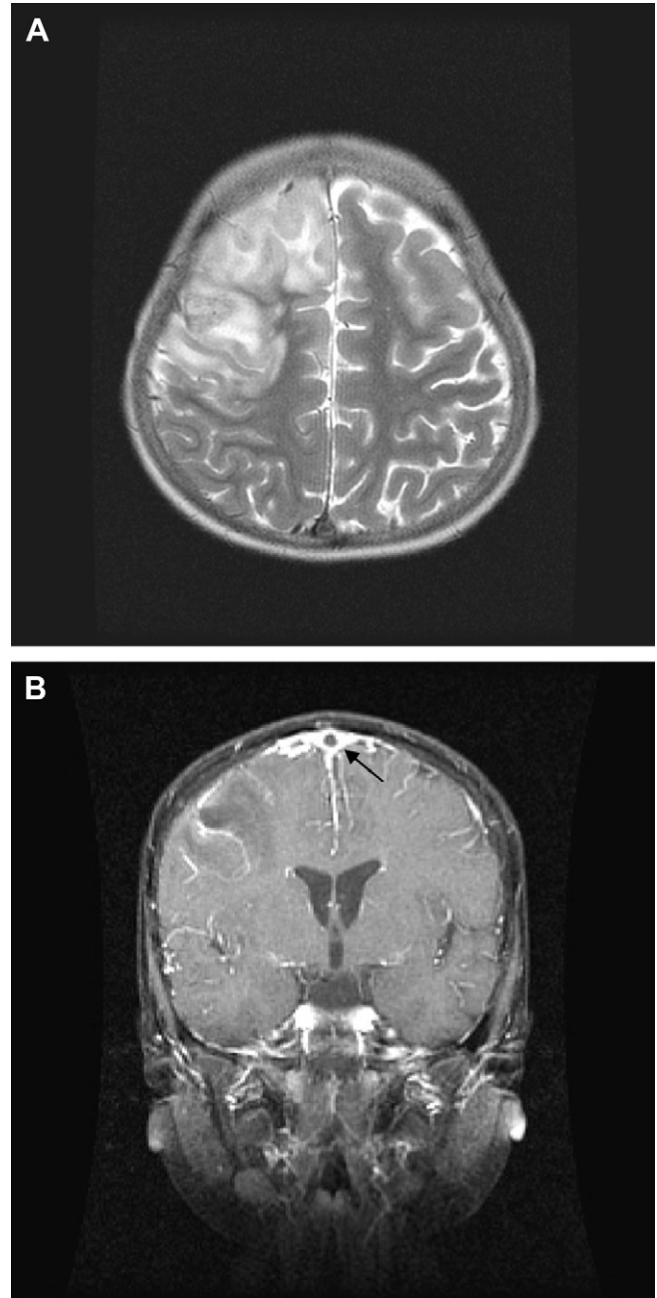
(A) Axial T2-weighted magnetic resonance imaging shows acute infarction involving right anterolateral and parasagittal frontal lobe and some foci of hemorrhage inside with “bright-up” on diffusion-weighted images. (B) Coronal T1-weighted magnetic resonance imaging reveals low-attenuating thrombus (arrow) within the superior sagittal sinus with “empty-delta” sign, surrounded by a triangular area of enhancement.
